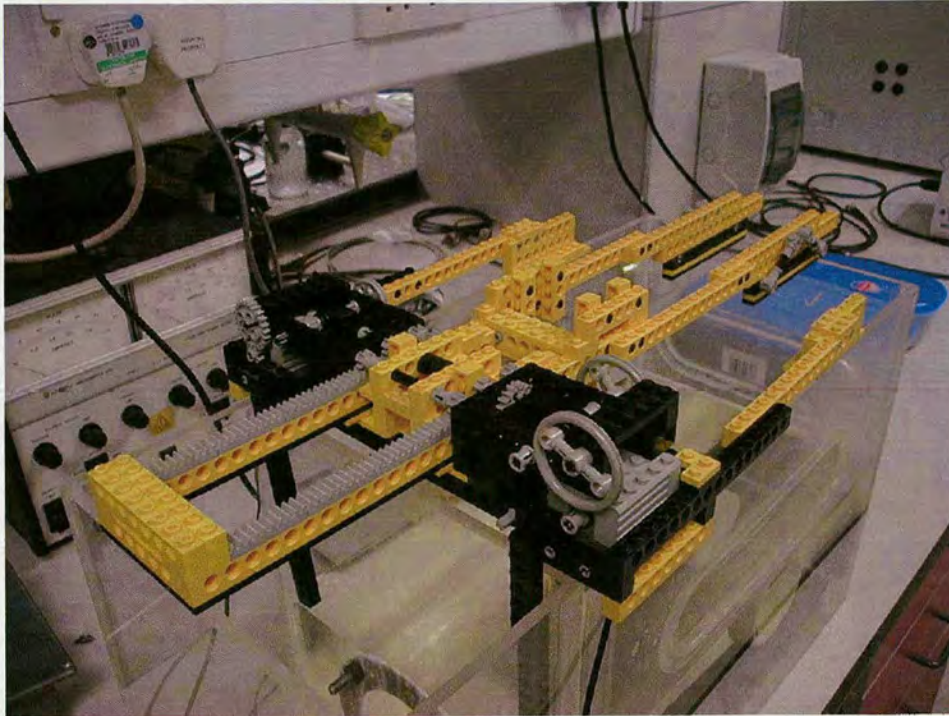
Photo of the mechanical scanner used to allow the single crystal ultrasound system to capture 2D images.*
